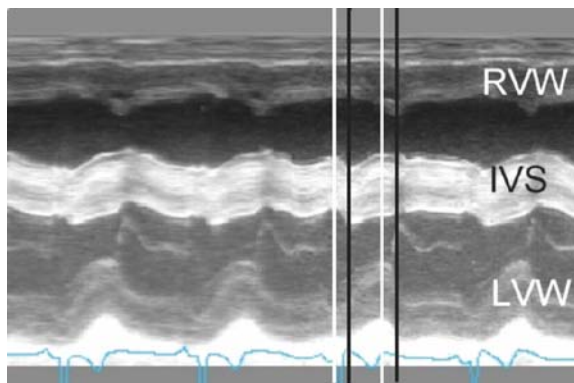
M-Mode from the right parasternal long-axis view. Asynchronous contraction of left ventricular free wall (LVW), interventricular septum (IVS) and right ventricular wall (RVW). Note the time delay between left ventricular mechanical systole (white bars) and right ventricular mechanical systole (black bars).
